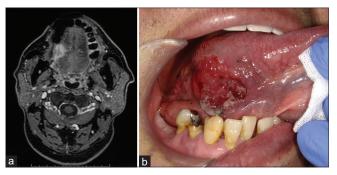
(a) MR image at the initial examination in case 1. (b) The markings before intra-arterial DCF therapy
